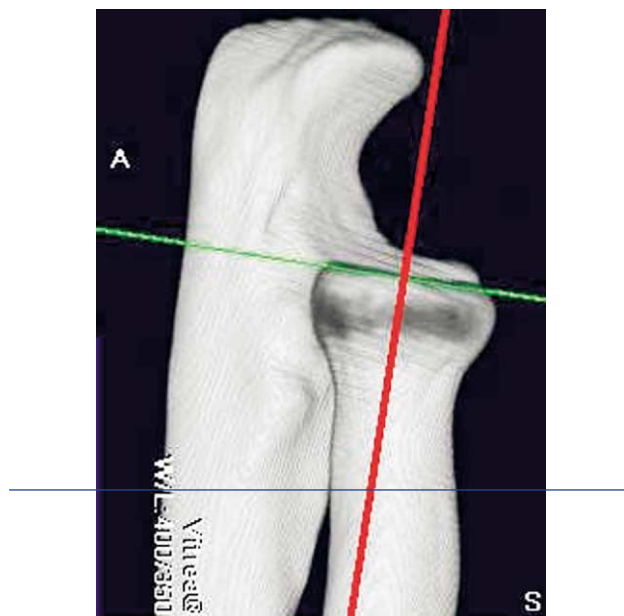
Image manipulation was performed (Vitrea 2 software; Vital Images, Inc., Plymouth, MN). For each patient 3-dimensional computed tomography images were used to determine a plane defined by the margins of the articular surface of the radial head (Fig. 1). A 2-dimensional image was created in a plane orthogonal to the articular surface of the radial head. The rotation of the plane was selected so that it connected 2 points: (1) a point at the center of the radial head (where lines representing the major and minor diameters of the somewhat elliptical radial head cross) and (2) a point on the central ridge of the coronoid at a point representing 50% of the total height of the coronoid process (Fig. 2). By using this image the distance between the plane of the articular surface of the radial head and parallel planes at the most proximal aspect of the coronoid (the central
